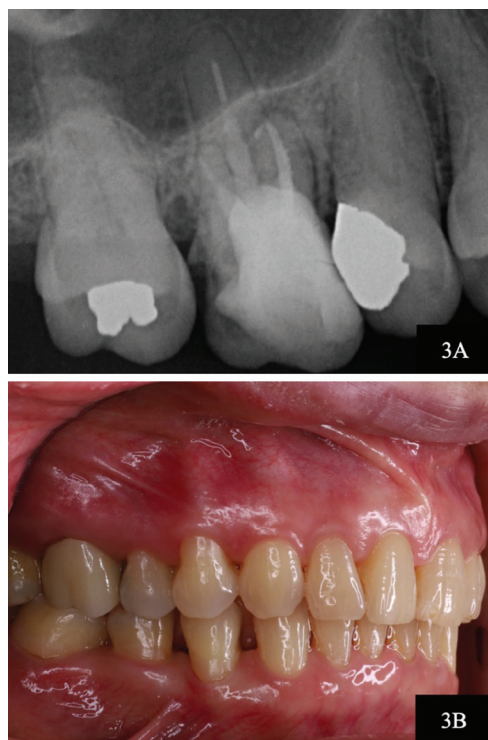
Postoperative outcomes. (3A) Post-obturation periapical radiograph; (3B) Intraoral photograph following coronal restoration.
